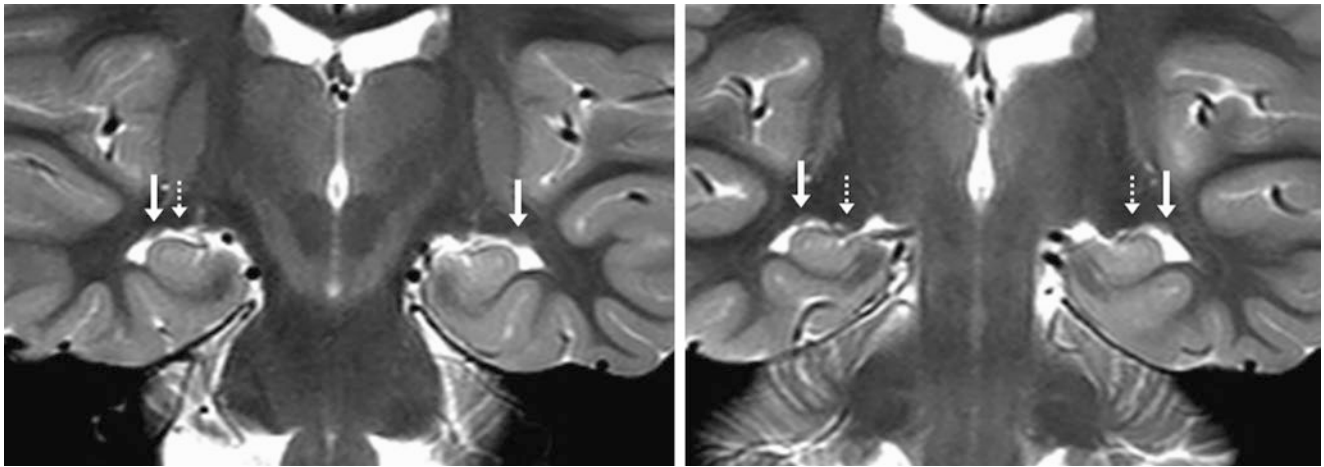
A 4 year old with seizures had a negative study. On a 3 T MRI, serial coronal T2WIs demonstrate that the caudate tails may be mildly asymmetric in size (in this case, the left was slightly larger than
